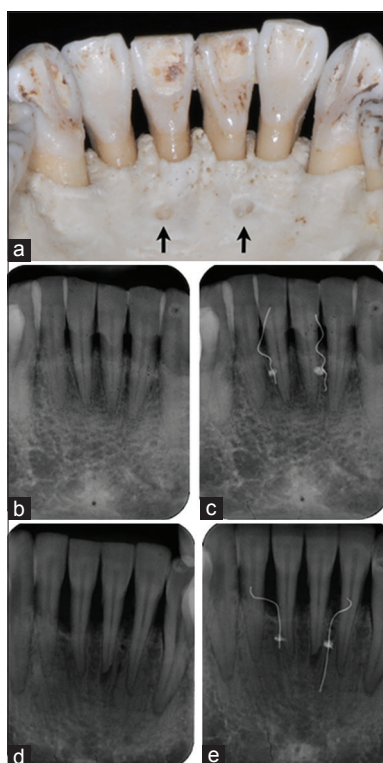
Anatomy of mandibular interalveolar medial foramina and the radiographic evaluation of the foramina. The lingual anatomy of mandible viewed from a dry skull (black arrows indicate the right and left interalveolar medial foramina). (a) Two radiographic films were taken from each mandibular skull (b and c or d and e), with (b and d) and without wire (c and e). For B, no clear radiolucency was observed to reveal the interalveolar medial foramen, while a radiolucent shadow with a canal shape (indicating by a white arrow) was easily observed on the film D
